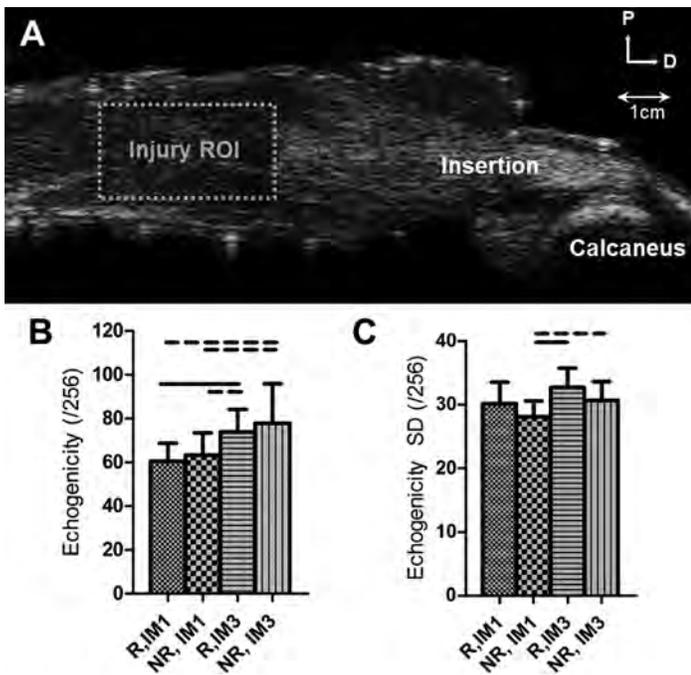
Achilles tendon structural evaluation using high frequency ultrasound (HFUS) following Achilles tendon rupture after receiving repair (R) or non-repaired (NR) treatments and aggressive (IM1) or moderate (IM3) rehabilitation. A region of interest (ROI) was chosen at the injury site located at the tendon midsubstance for subsequent analysis (A). Moderately rehabilitated tendons demonstrated either a significant or trend toward increased echogenicity mean (B) compared to the aggressive rehabilitation groups. Increased echogenicity standard deviation (C) was present in R tendons with moderate rehabilitation compared to NR tendons with aggressive rehabilitation.
